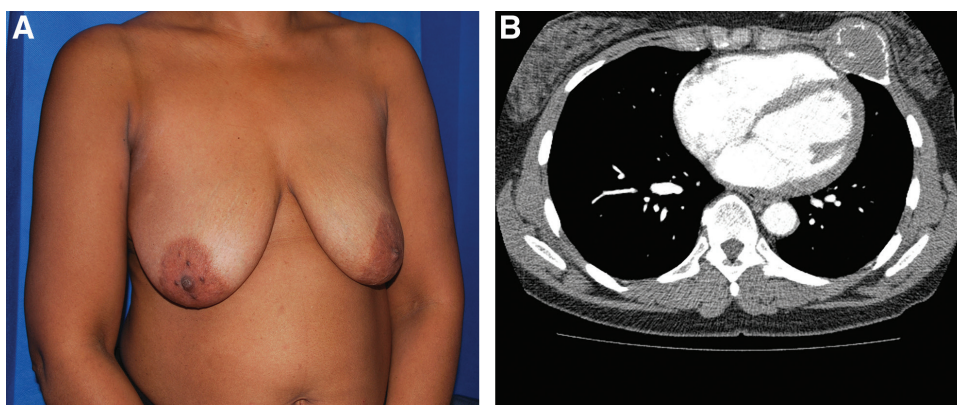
A 47-year-old patient with a giant cell tumor in the anterior left chest wall. A, preoperative photo showing breasts, cup size C, with grade III ptosis. B, CT scan of the thorax revealing a giant cell tumor of the left fourth rib in midclavicular line.
